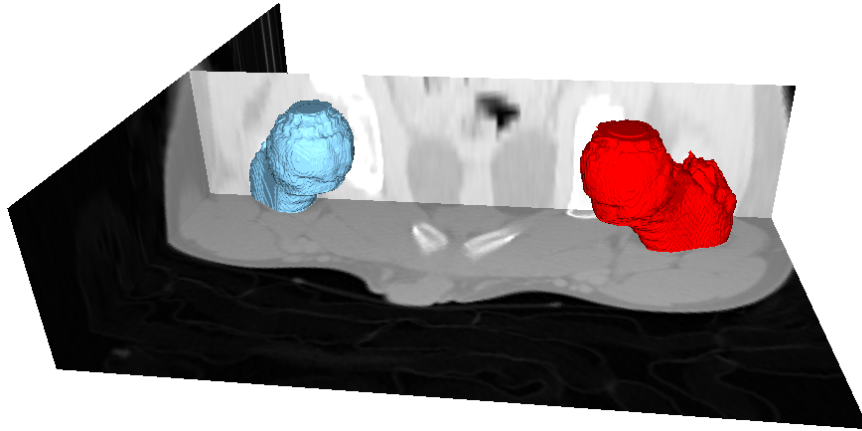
A segmented CT scan. The image shows a view from the software Seg3D.
